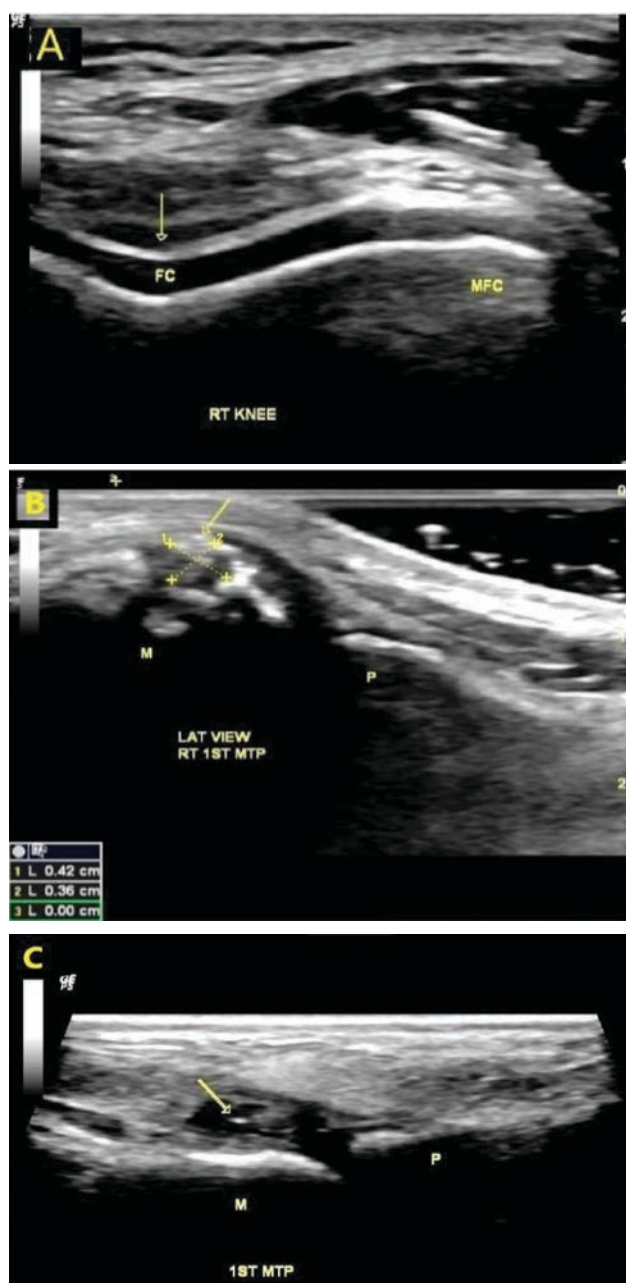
Ultrasound grayscale. A: DC sign over the femoral cartilage of the RT knee, B: Tophus measuring (42×36 mm) with underlying erosion at the right 1st MTP. C: Aggregate at the 1<sup>st</sup> MTP joint. 1st MTP: first metatarsophalangeal joint, M: metatarsal bone, MFC: medial femoral cartilage
